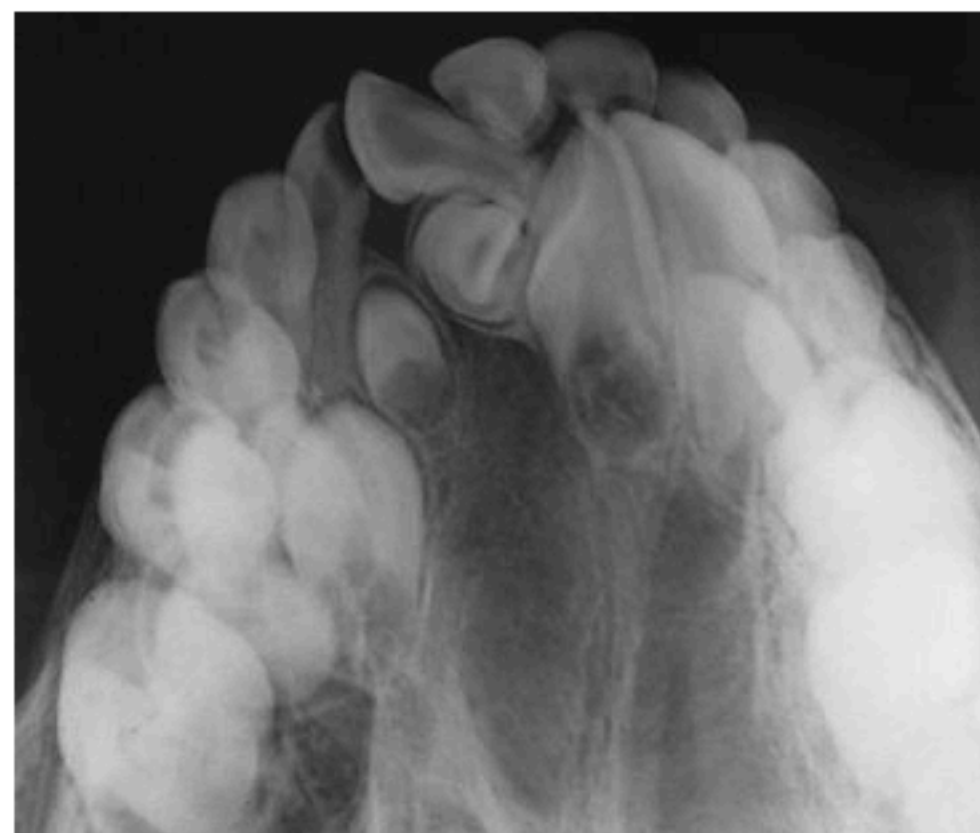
Maxillary occlusal radiograph demonstrating supernumerary maxillary central incisors.
